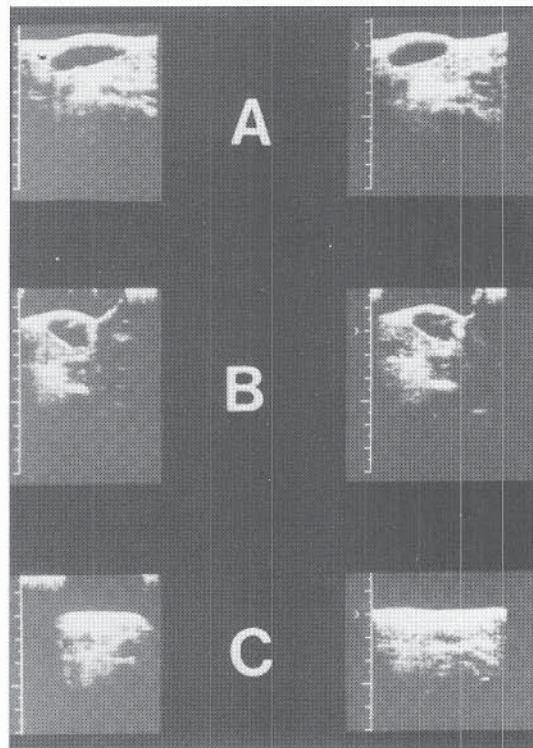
Sonograms of both knees showing a popliteal cyst on the right. A and B, Sagittal images showing a large echo-free mass in the popliteal fossa of the right knee. C, The normal left knee.
